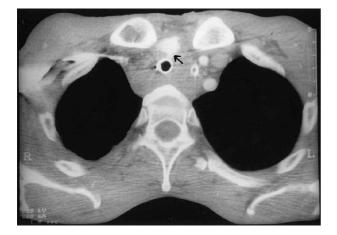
CT angiogram showing the fistulous communication between the trachea and innominate artery.
